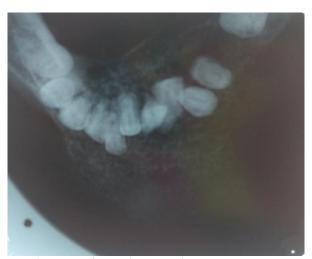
Occlusal Radiograph of anterior mandible shows coarse trabecular pattern
